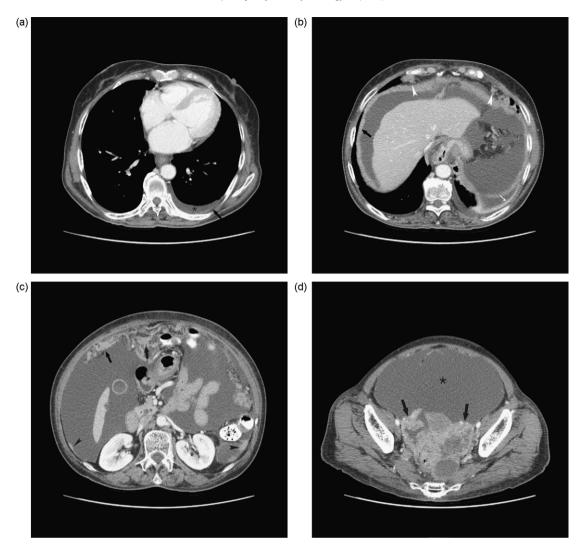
Malignant pleural effusion in 72-year-old woman with bilateral ovarian serous cystadenocarcinomas. (a) Contrast-enhanced CT scan shows small amount of pleural effusion in left pleura (asterisk). Note thickening of left parietal pleura (arrow). (b) Contrast-enhanced CT scan shows peritoneal implant in subdiaphragmatic area (large arrow) and parietal pleural thickening (small arrow). Note enlarged supradiaphragmatic lymph nodes (arrowheads). (c) Contrast-enhanced CT scan shows nodular thickening of peritoneum (arrowheads) and omental cake (arrows). (d) Contrast-enhanced CT scan shows solid and cystic ovarian masses in both adnexa (arrows). Note large amount of ascites (asterisk).
